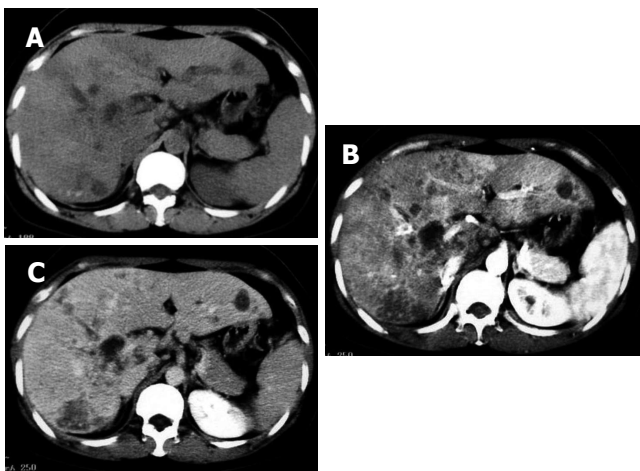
Abdominal computed tomography (CT). A: Plain CT images show intrahepatic ductal dilatation, micro-calcifications, and multiple hypodense lesions in the liver; B: Contrast CT image (early phase) shows clearly delineated hypodense lesions; C: Late phase CT image shows slightly enhanced hypodense lesions.
